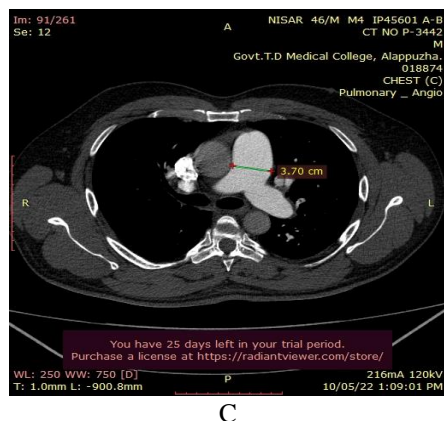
CT Pulmonary angiogram showing emboli in the R main pulmonary artery and L segmental arteries and © the dilated pulmonary trunk suggestive of pulmonary artery hypertension
